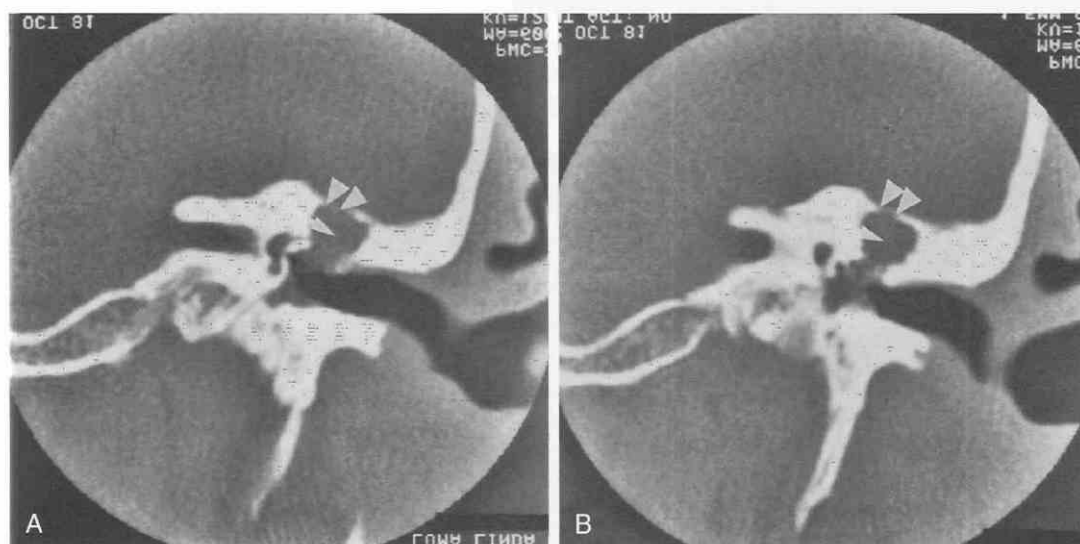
Epitympanic cholesteatoma in an elderly woman with a long-standing history of vertigo and left-sided hearing loss. A and B, Coronal CT scans of the left ear show a large, destructive soft tissue mass in the tympanic cavity, epitympanic space, attic, and antrum (arrows). The scutum is thinned. The walls of the middle ear cavity are expanded and amorphous. There is erosion of the cholesteatoma into the lateral semicircular canal. The tympanic membrane is retracted. The tegmen antri is thin, but there is no evidence of intracranial extension (arrowheads).
